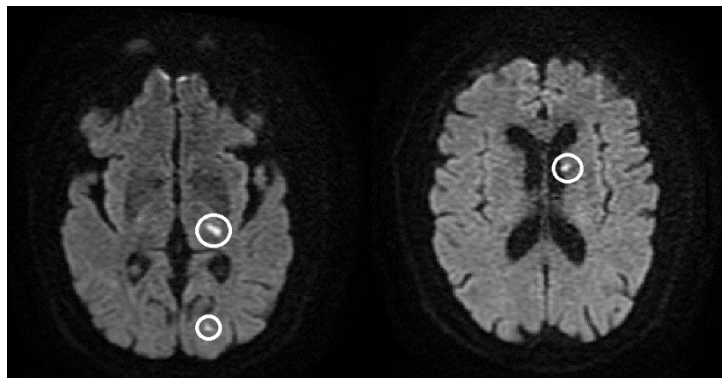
MRI brain with two infarcts (circled) in left image and one infarct (circled) in right image.
